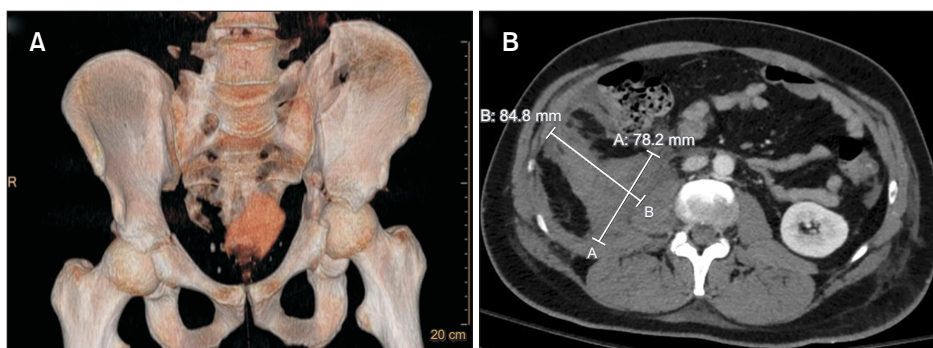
(A) Computed tomography (CT) showed multiple pelvic fractures. (B) CT depicted a sizable retroperitoneal hematoma in the lesser pelvis.
